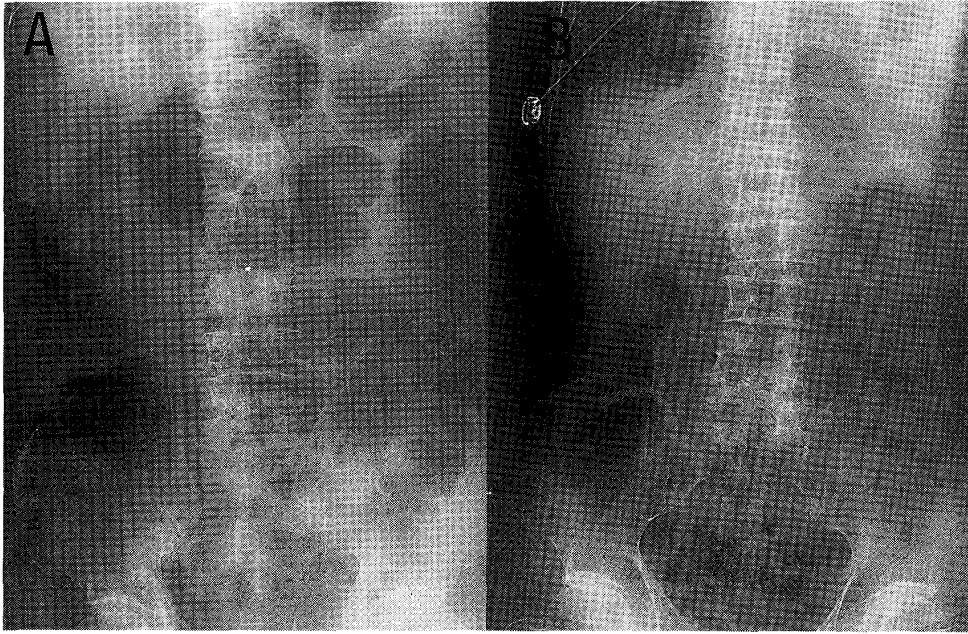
Plane X-ray films of the abdomen in cases 1 (A) and 2(B) show gaseous distension of the small and large bowel.
